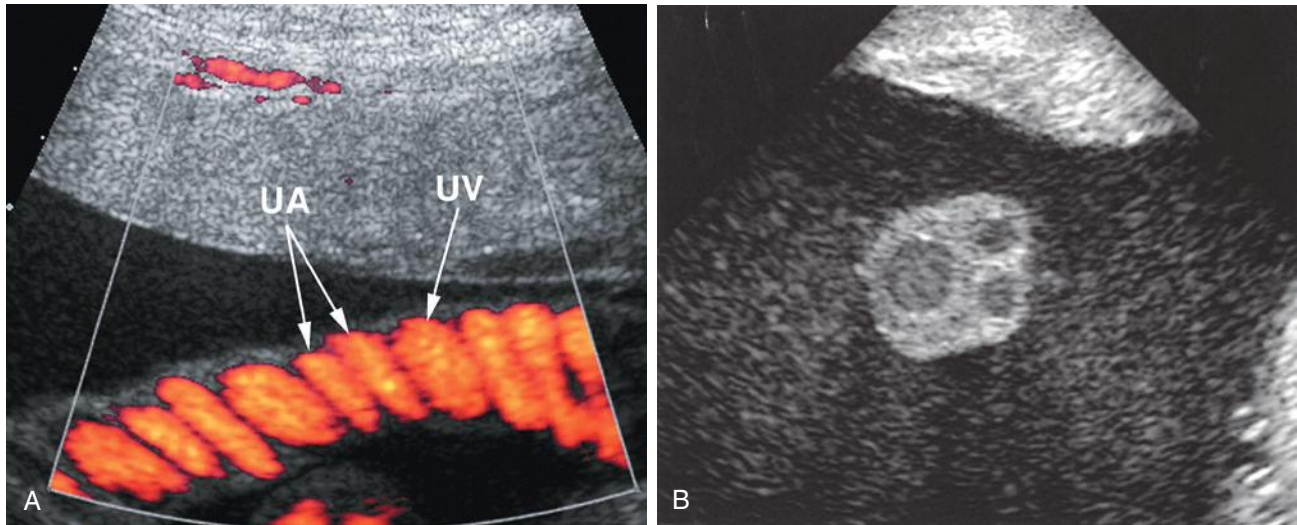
A, Longitudinal nondirectional color Doppler sonogram of the umbilical cord. The umbilical vein (UV) is interlaced by the two umbilical arteries (UA). B, Transverse axial sonogram of the umbilical cord.
